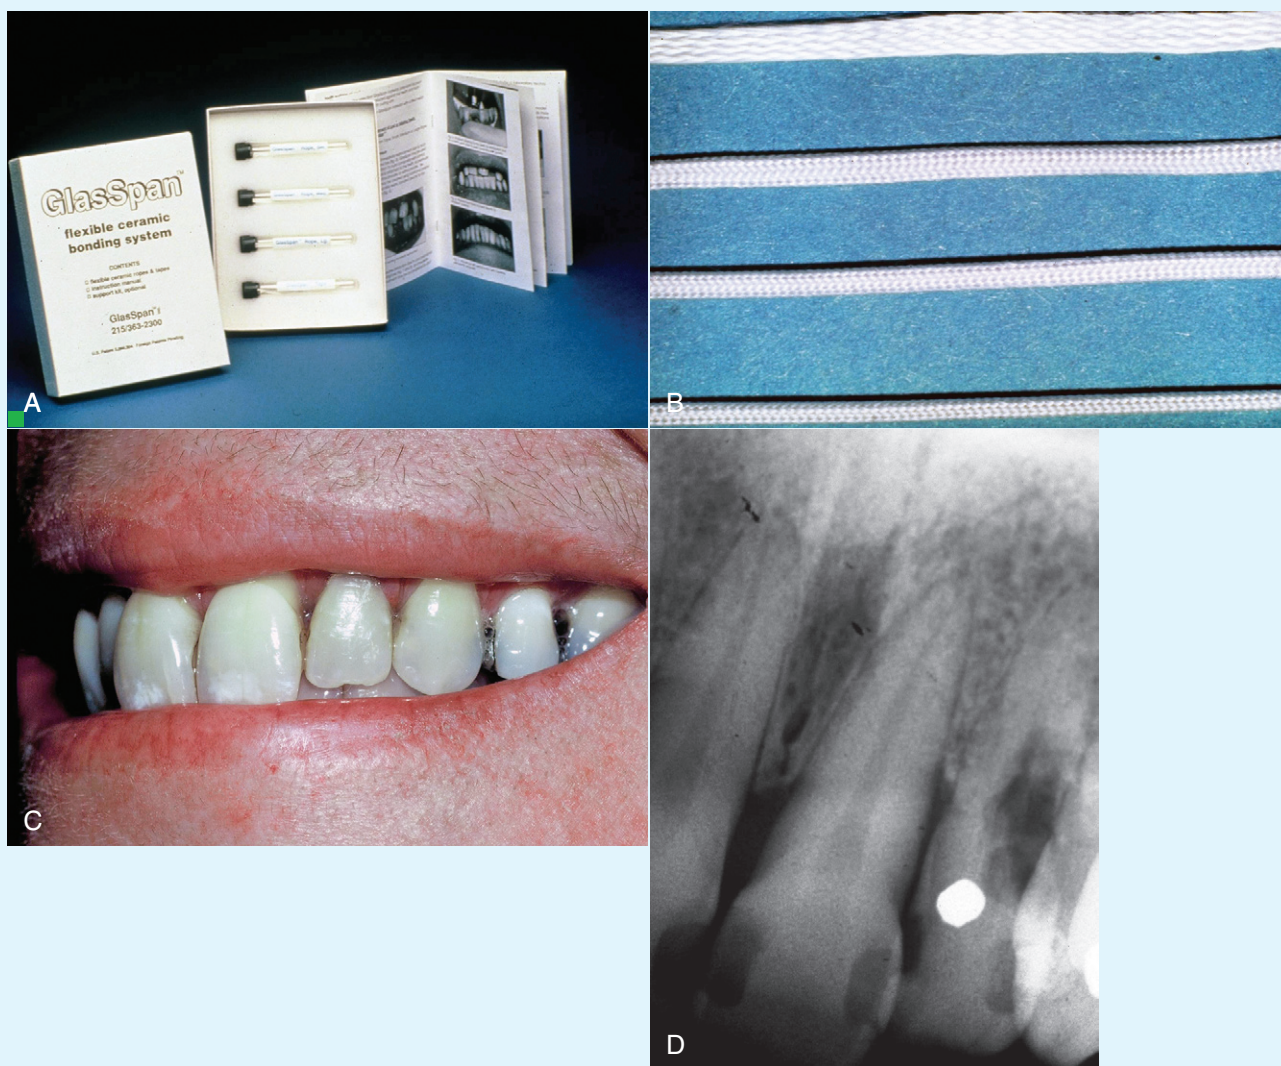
A, The GlasSpan fiber reinforcement system. B, Flexible strength members in braided rope and tape configurations. C, Inflammation and suppuration surrounding patient's maxillary left lateral incisor. D, Radiograph showing advanced external resorption.
